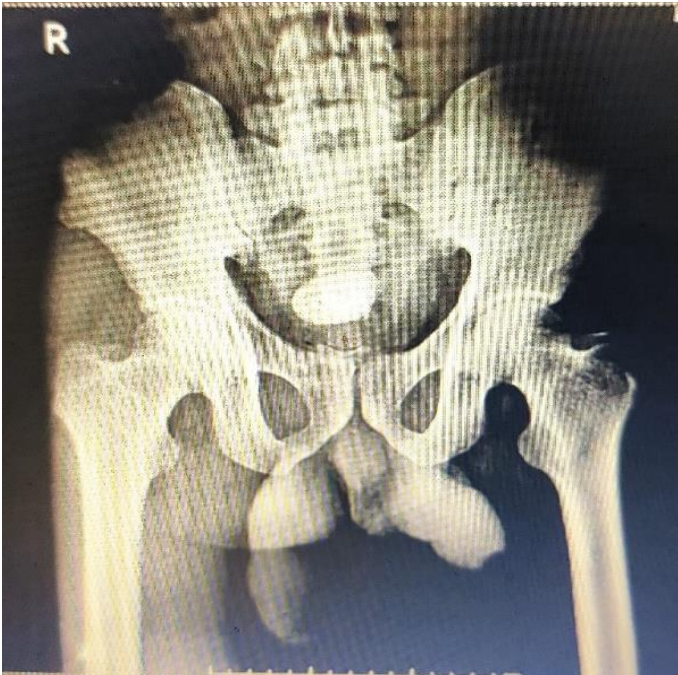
x-ray KUB showing Vesical calculi.
